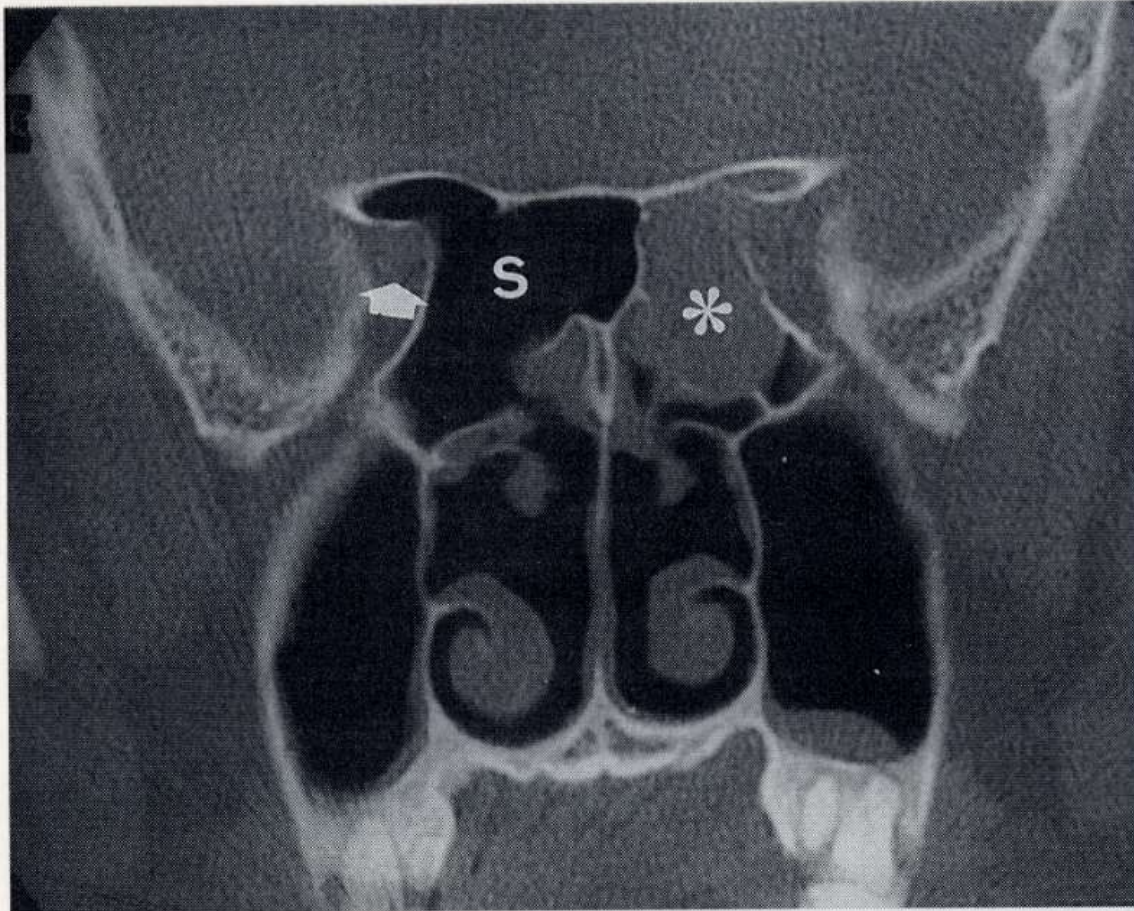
Coronal CT shows the relationship of the right optic nerve (arrow) and the sphenoid sinus (S). Note the mucosal thickening in the left sphenoid sinus (asterisk) and potential risk to the left optic nerve during surgery.
